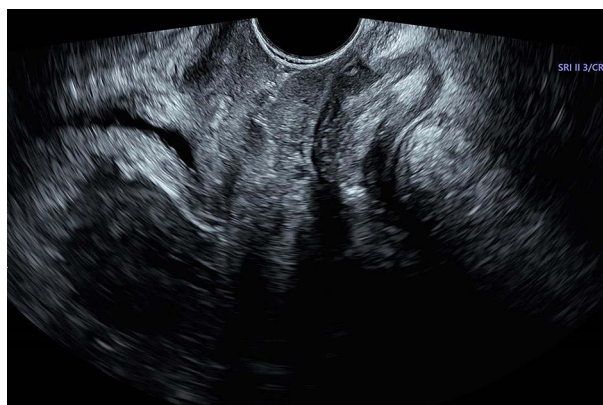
Vaginal ultrasound showing a dark, liquid area (2020.06.10).
